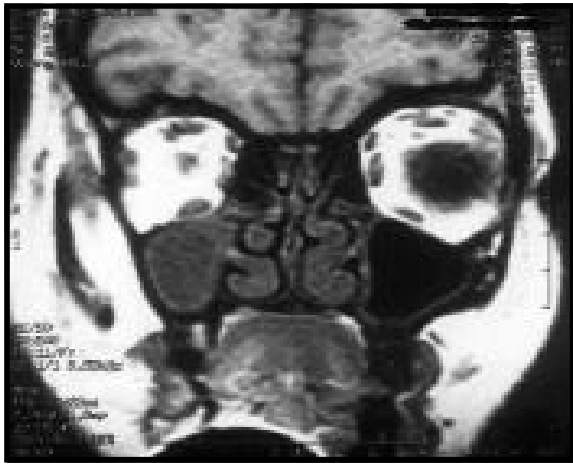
(a) T1 weighted coronal MRI image showing overt signs of right sided maxillary sinusitis. (b) T1 weighted horizontal MRI image showing overt signs of right sided maxillary sinusitis.
